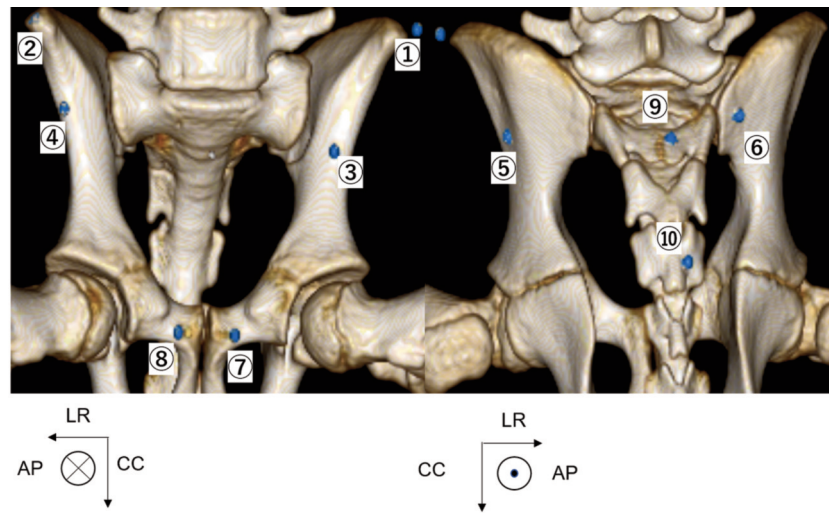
Three-dimensional computed tomography showing 10 markers (indicated by the 10 numbers) placed around the pelvis. LR: Left-right, AP: anterior-posterior, CC: cranio-caudal.
